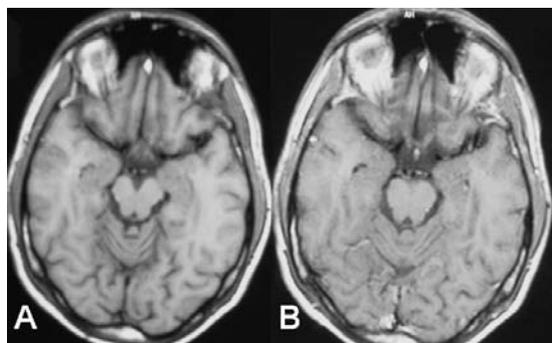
Axial magnetic resonance images of a 21-year-old male patient with miliary tuberculosis 4 months after antituberculosis chemotherapy. (A) T₁-weighted magnetic resonance image (640/14) shows nothing remarkable at the level of the midbrain. (B) Contrast-enhanced T₁-weighted magnetic resonance image (640/14) shows nothing remarkable at the level of the midbrain.
